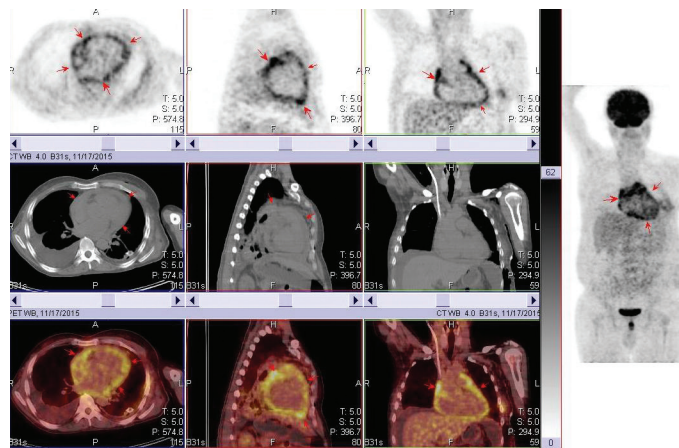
F-18 FDG MIP PET (upper), CT (middle), and fusion PET/CT (lower) images of the thorax show a diffuse intense F-18 FDG uptake (SUVmax, 7.5) in the thickened pericardium. There is fluid collection within the pleural spaces
